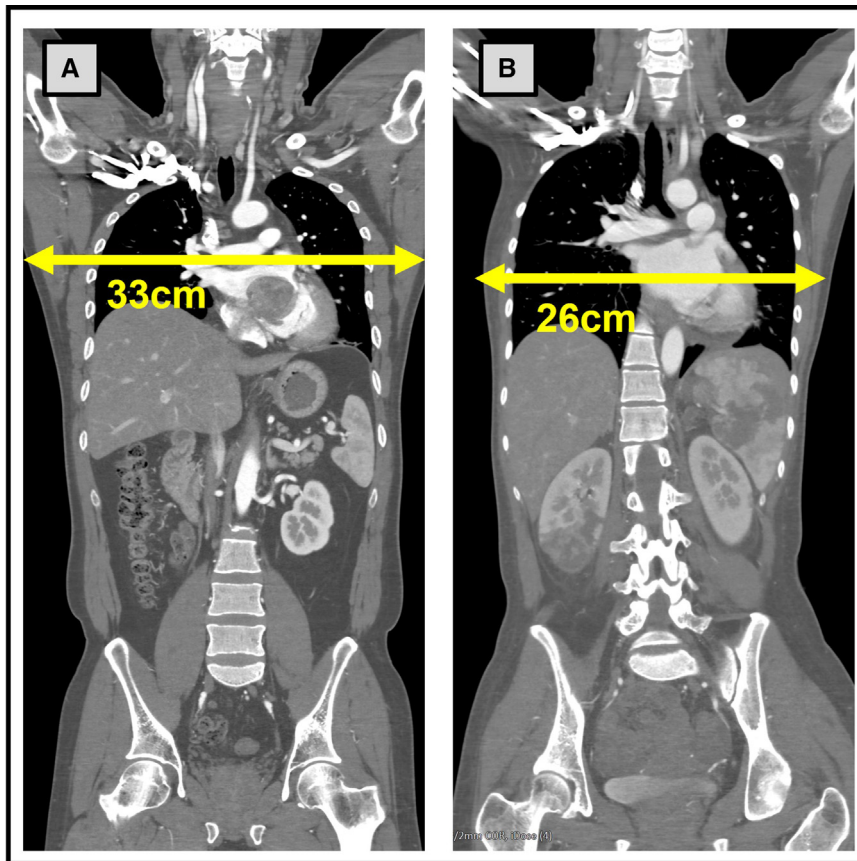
Preoperative computed tomography (CT) images to determine working port location. When the intercostal spaces were small, the main incision was made at the fifth intercostal space to avoid instrumental interference. A, Preoperative CT scan for a male patient with the main incision at the fourth intercostal space. B, Preoperative CT scan for a female patient with the main incision at the fifth intercostal space.
